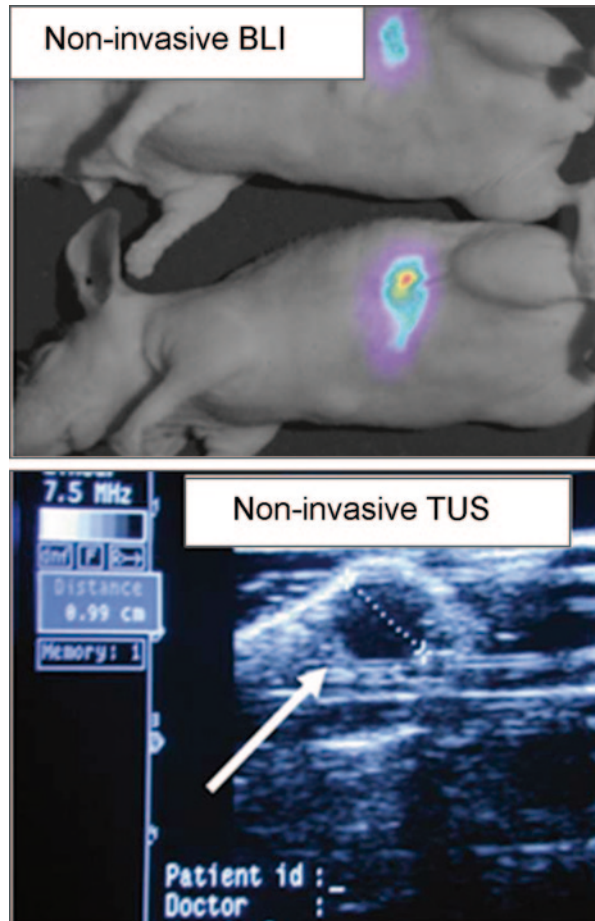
Noninvasive imaging of tumor and metastatic growth. Using luciferase labeled cells; tumor growth after orthotopic implantation can be followed using BLI (*upper panel*). The tumor intensity is measured and can be followed over time. Without labeled cells, simple ultrasound imaging can provide evidence of tumor growth that is measurable (*lower panel, dotted line is tumor measurement*)
